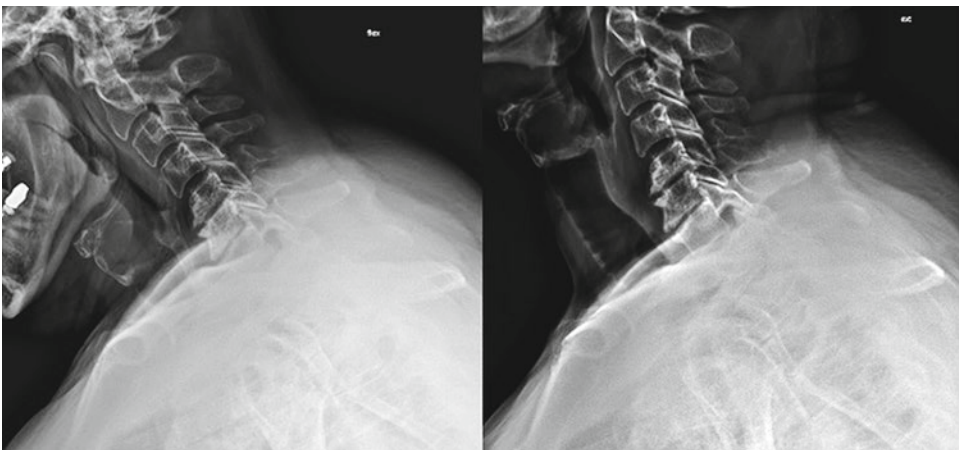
Flexion/extension radiographs demonstrating stable appearance of spondylolisthesis
